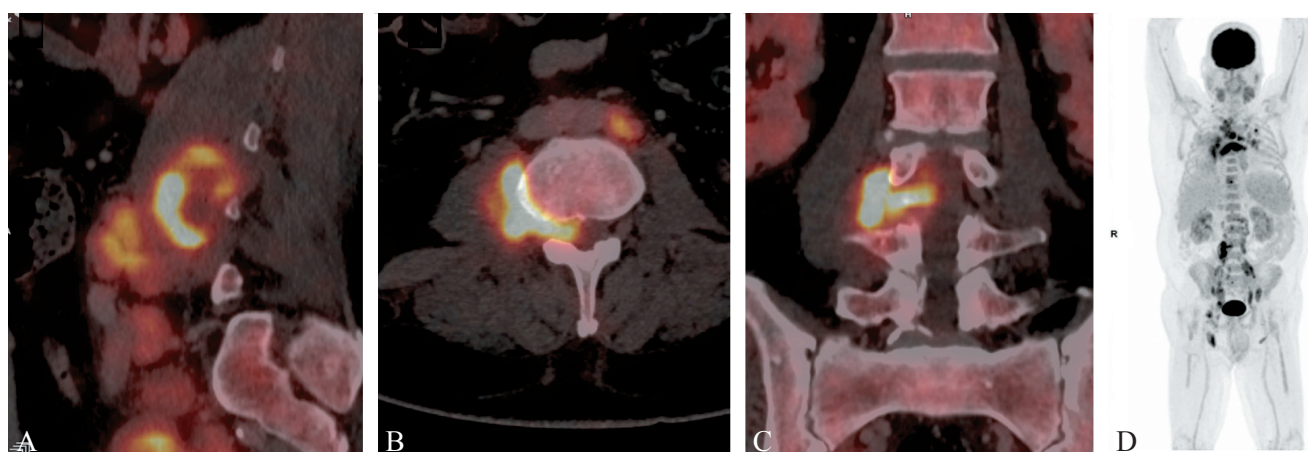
Sixty-five-years-old patient immunosuppressed man with HIV. ^{18}F -FDG shows a markedly increased uptake at the right side of the L3-L4 vertebral endplates, extending laterally into the right psoas muscle and posteriorly into the vertebral canal, corresponding to spondylodiscitis with psoas abscess and epiduritis. Mycobacterium tuberculosis infection was confirmed by bone biopsy. Sagittal (A), axial (B) and coronal (C) fused PET/CT images and MIP image (D).
